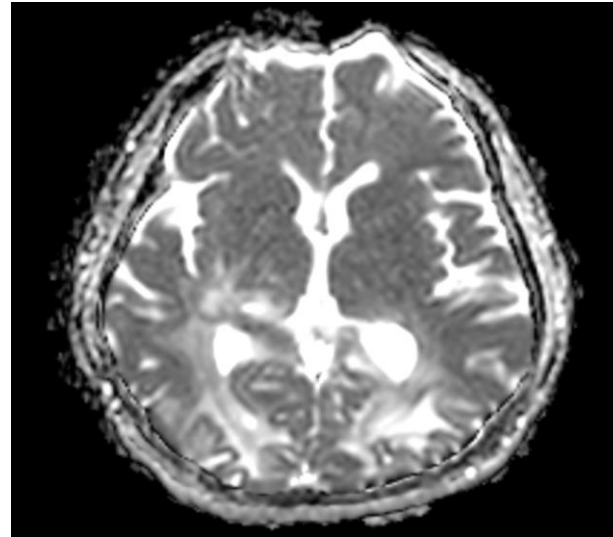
MRI showing T-2 weighted signal abnormalities involving the white matter of the parietal and occipital lobes bilaterally.
